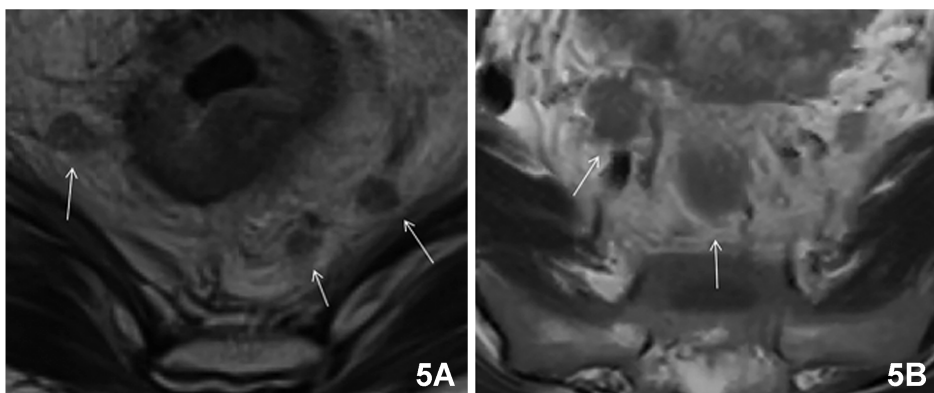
MRI of lymph node metastasis in RMAC and conventional rectal adenocarcinoma<sup>[15]</sup>
